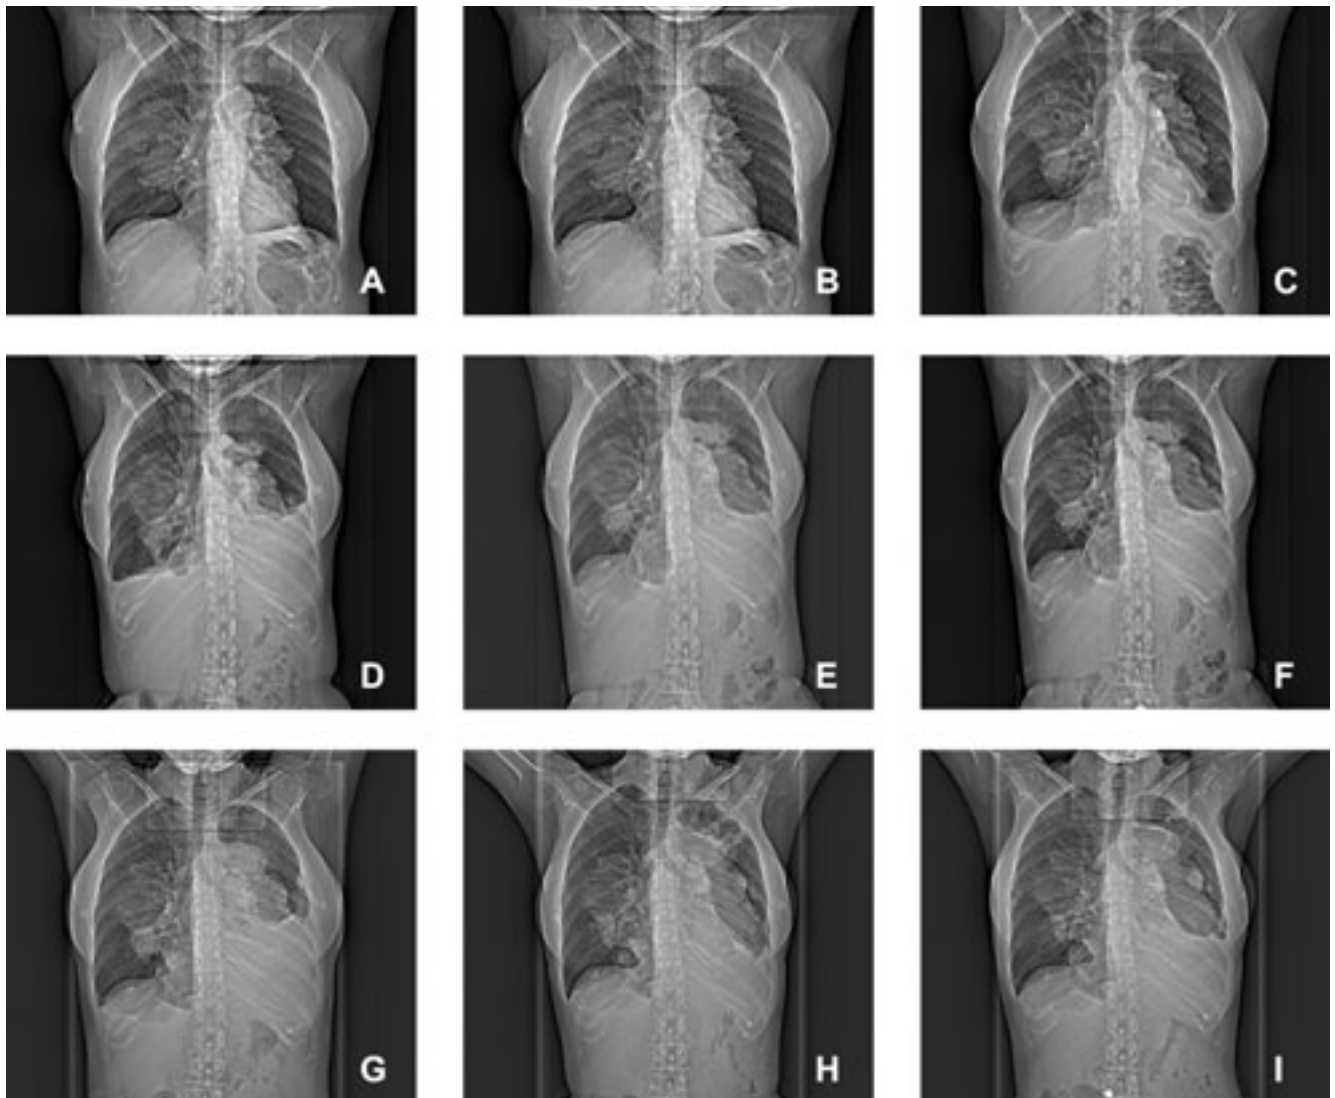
Coronal computed tomography scan overview of the patient's thorax with metastasized myxopapillary ependymoma. Findings and clinical symptoms: A) three pleural masses and multiple pulmonary nodules, a small encapsulated pleural effusion on the left side; B) progression of intrapulmonary nodules and of the pleural effusion on the left side; C) progression (dyspnea on exertion, thoracic pain, weight loss); D) progression of pleural effusion (dyspnea at rest); E) decrease of pleural effusion, but increase of tumor masses (hoarseness); F) stable disease (dry skin, paraesthesias, hoarseness, aphthae and films in the mouth, pain); G) stable disease (sleep disturbances, pain, hypertension); H) stable disease (weakness); I) stable disease (weakness and mixed axonal polyneuropathy in 3/11). Antineoplastic therapy: start temozolomide (B), start imatinib (C), reinduction imatinib (E), sorafenib (F), dose reduction because of suspect metastases in the spinal cord, reinduction of the full dose (G), sorafenib ongoing (H, I).
